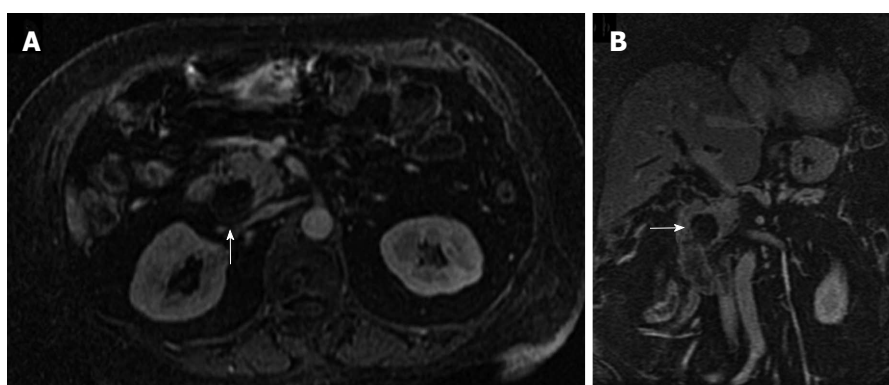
Axial arterial-phase gadolinium-enhanced T1-weighted fat-suppressed gradient-recalled echo magnetic resonance imaging (A) and coronal re-formatted (B) show no enhancement of the hypovascular tumor in the pancreatic head (arrow). Pancreatic adenocarcinoma was proven by biopsy.
